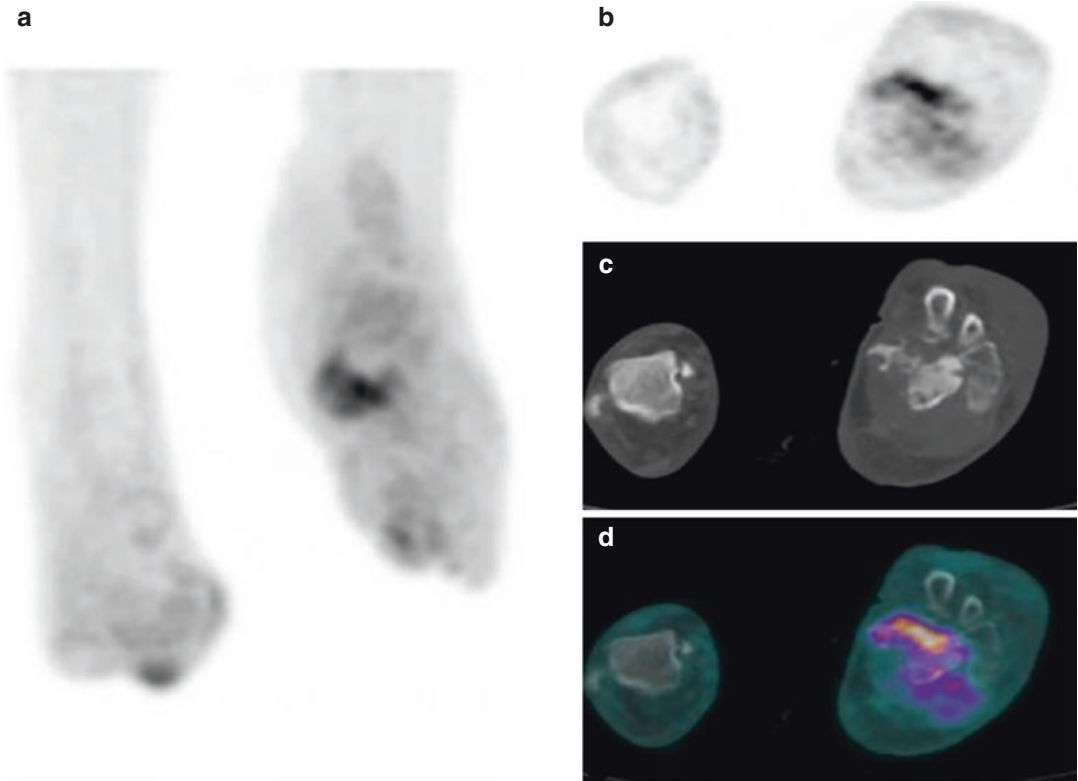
^{18}F -FDG PET/CT imaging in a diabetic foot: PET 3D maximum intensity projection (a) and PET axial view (b) show intense tracer uptake in the left tarsal
